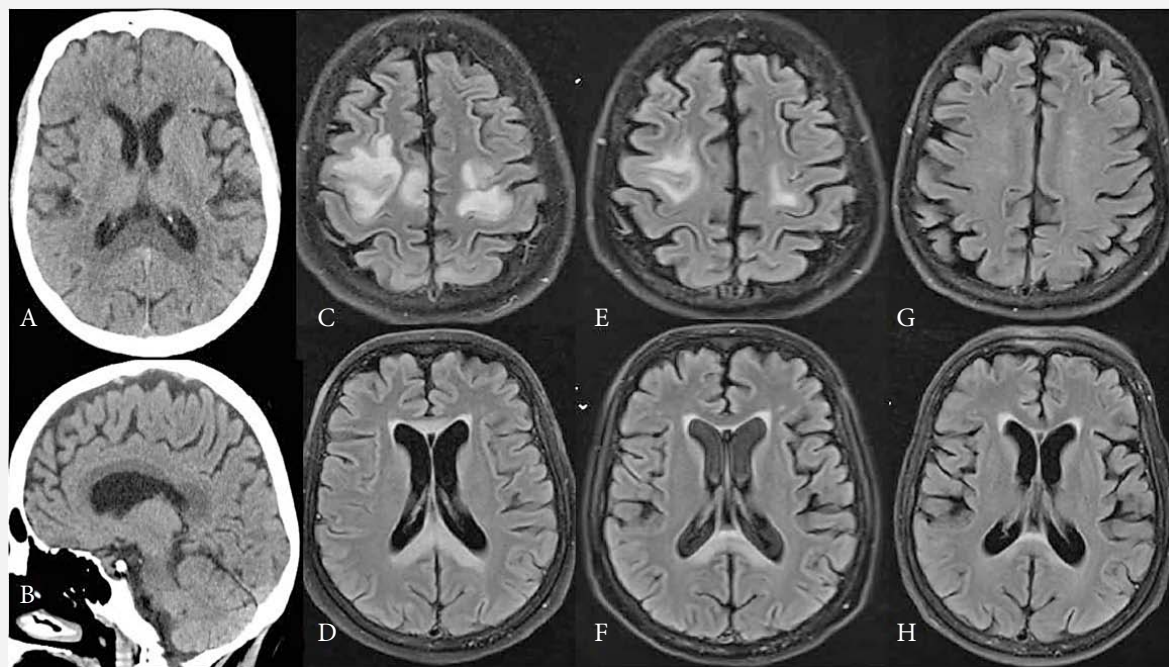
A axial, and B sagittal brain CT images showing edema of the splenium of the CC; C-H axial FLAIR images: C-D acute onset of the disease: prominent frontal bilateral white matter and CC lesions; E-F first follow-up brain MRI: moderate regression of brain lesions; G-H second follow-up brain MRI: almost complete regression of the brain lesions
